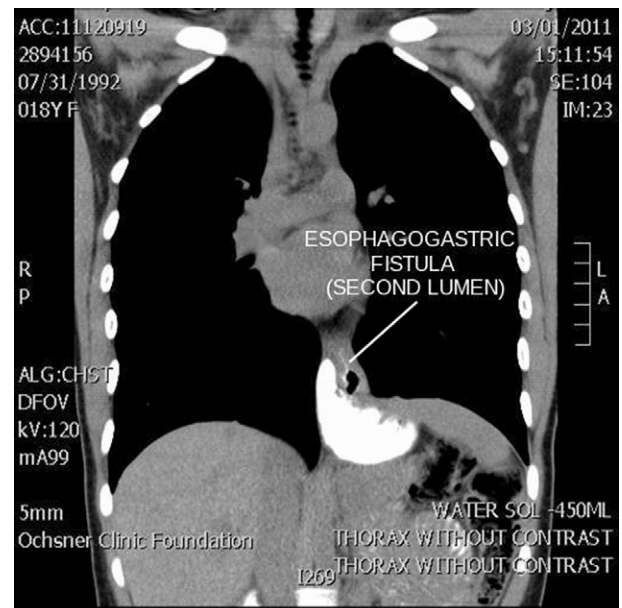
Preoperative CT esophagogram with Coronal reconstruction showing paraesophageal herniation and a small secondary esophagogastric lumen.
